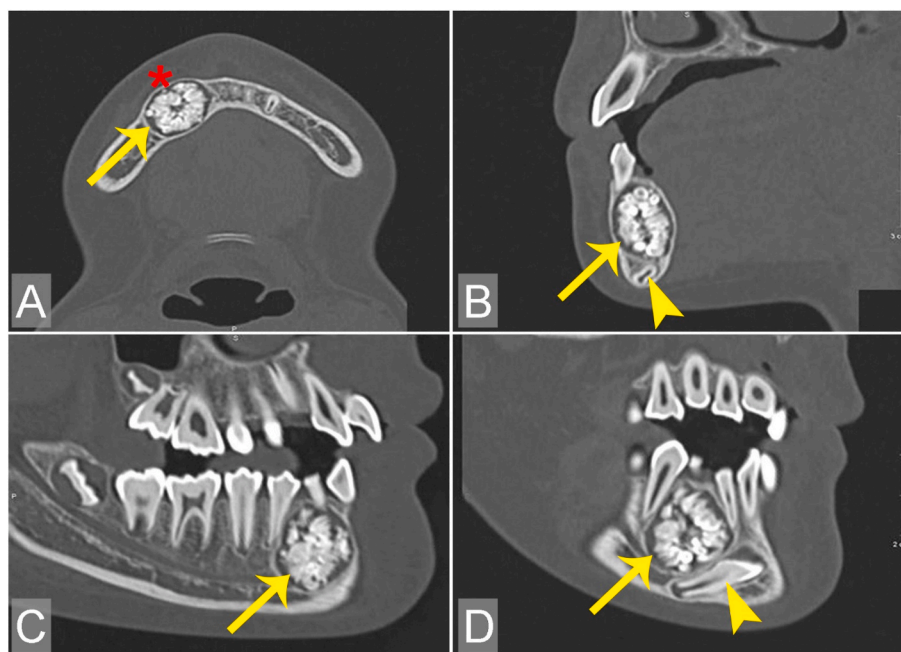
Compound odontoma of the mandible on the axial (A), sagittal (B), and oblique (C, D) CT images show mass with thin and clear bone margins. It causes bulging and thinning of the bony cortex but does not damage the bone structure (asterisk). Inside the lesion shows hyperdense structures tooth-like with a quite clear demarcation (arrows). Similar to the radiograph, the inferiority of the lesion presenting the 4.3 impacted tooth is retained and displaced (arrowheads).
